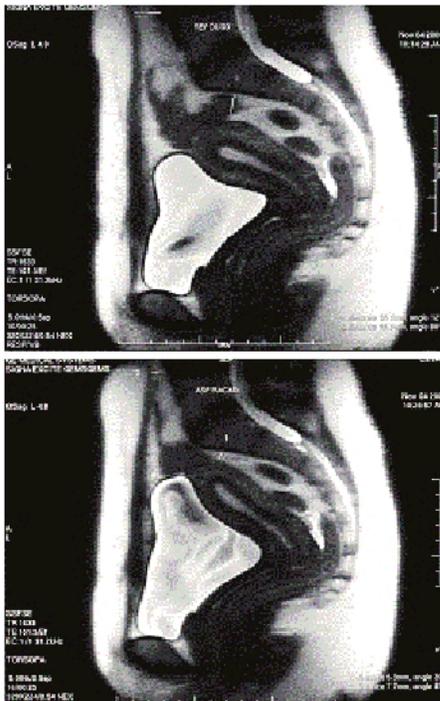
Ultrasound of the angle between the urethra and the bladder wall during the diaphragmatic aspiration.
